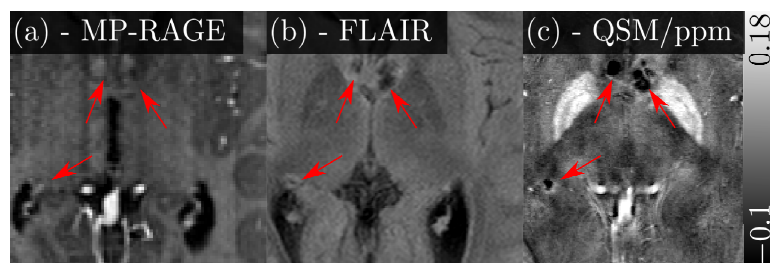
Patient A with bilateral calcified lesions adjacent to the caudate nucleus and right trigonum (arrows). Post Gd MP-RAGE and non-enhanced FLAIR image are shown in (a) and (b). All lesions were hypointense on the susceptibility map indicating substantial (diamagnetic) calcification.
